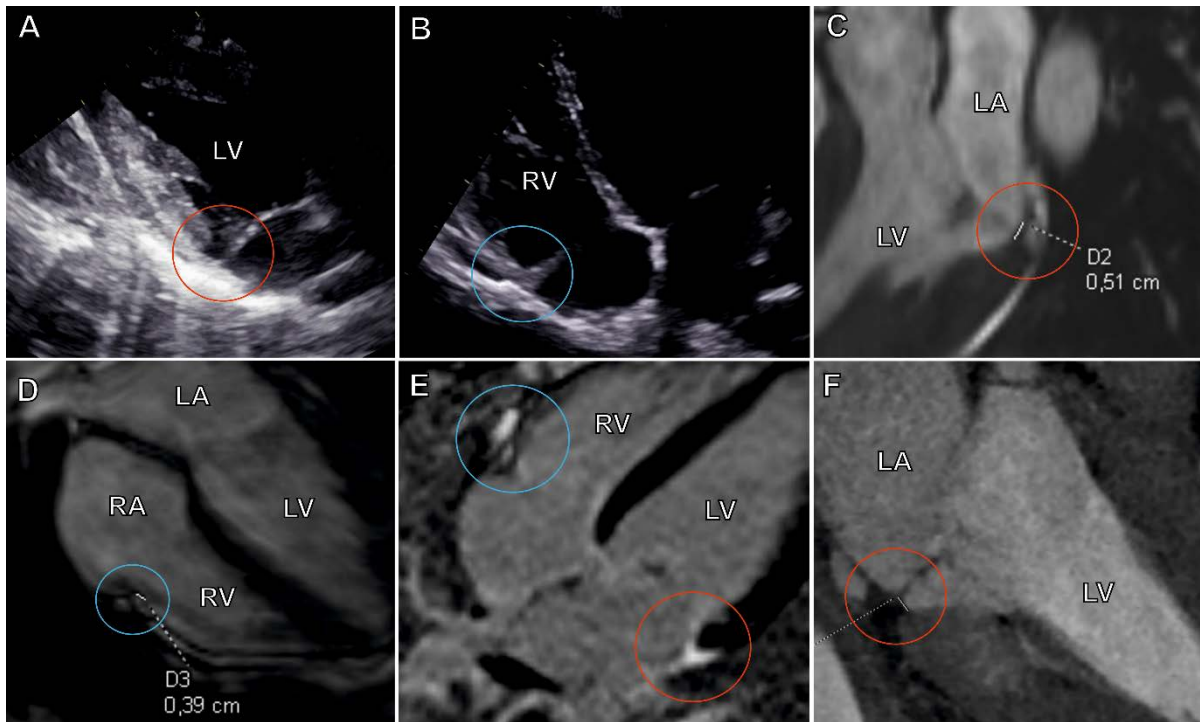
Biannular atrioventricular valve disjunction. Transthoracic echocardiography images showing the mitral annular disjunction (A) and tricuspid annular disjunction (B). Cardiac magnetic resonance examination with visible mitral annulus disjunction (C) and tricuspid annulus disjunction (D). Cardiac magnetic resonance examination with late gadolinium enhancement visible within the tricuspid and mitral annuluses (E). Contrast computed tomography with visible mitral annulus disjunction (F)
